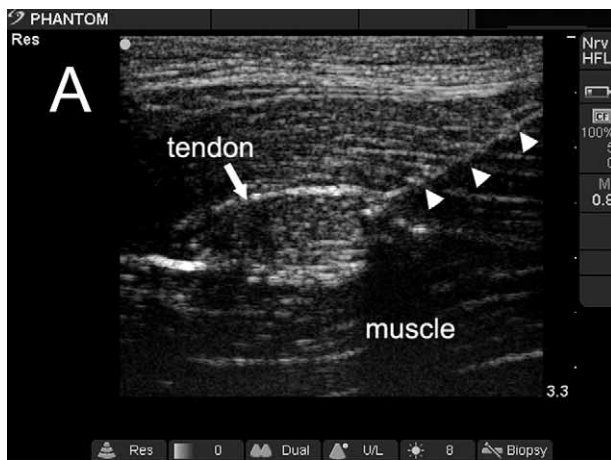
(A) Transverse sonogram of a tendon with a needle (arrowhead) in contact. (B) Longitudinal sonogram of a tendon with a needle (arrowhead) in contact. (C) Transverse sonogram of a hypoechoic collection after saline injection.
